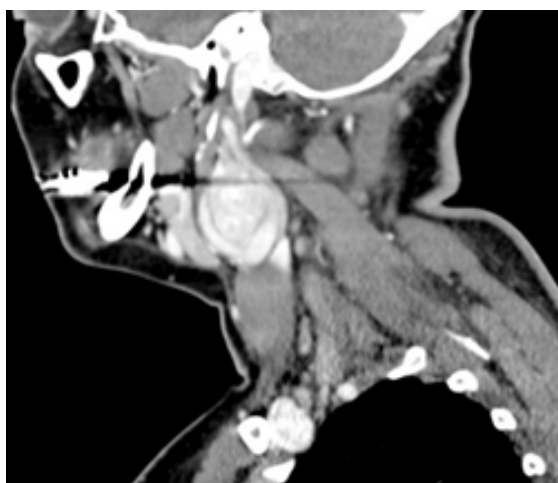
Sagittal soft tissue window, 2 mm slice thickness, contrast-enhanced CT.
